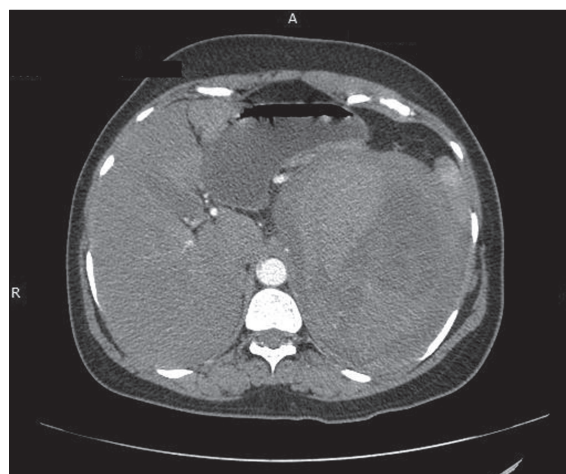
Axial contrast-enhanced computed tomography (CECT) image of left adrenal tumor
